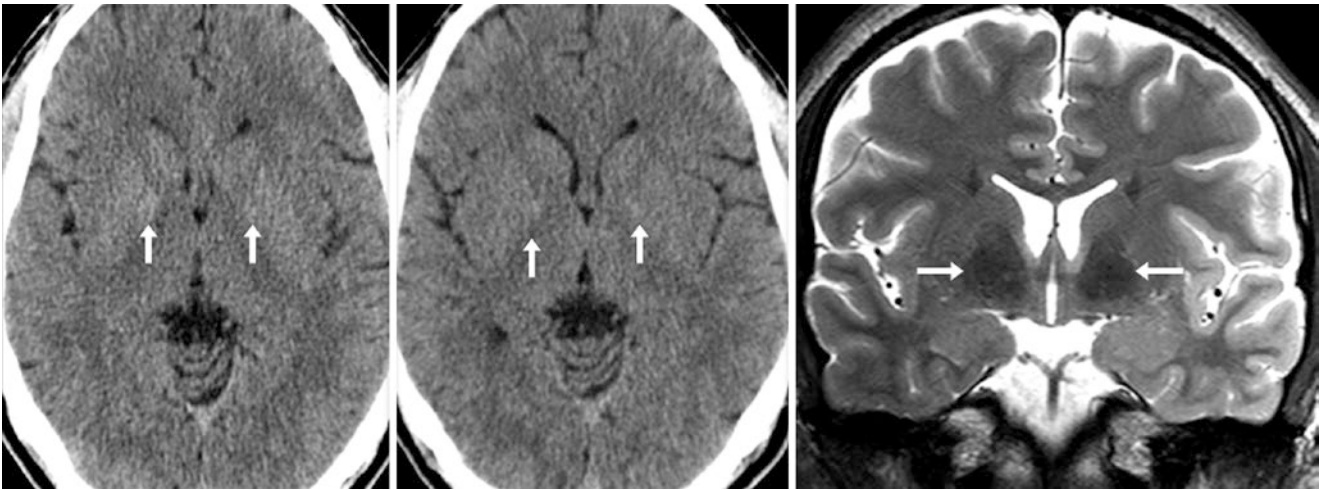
A 27 year old with faint, early, BG calcifications (*arrows*) on NECT (*left*) that were unchanged 1 year later (*middle*). A coronal T2WI MRI at 3T (*right*) showed dark signal of the globi pallidi (and to a lesser degree the putamina) probably also related to iron deposition, since the region of dark signal on T2WI is larger than that of calcium on NECT
